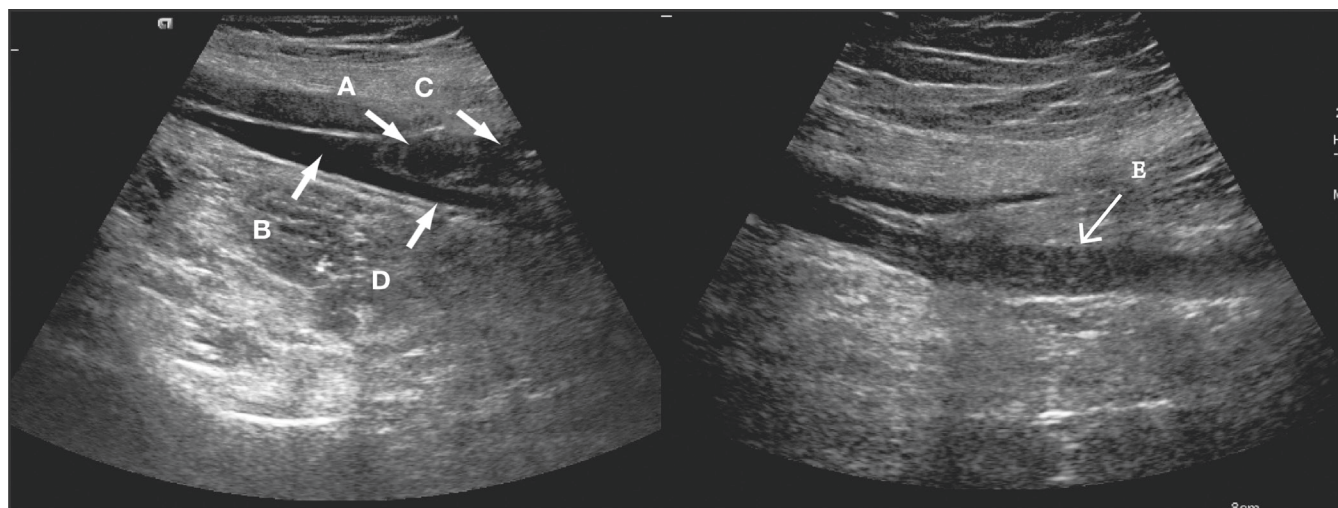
Ultrasound images show formation of DVT in the left lower extremities. (A) Head of the DVT (left). (B) Common femoral vein (left). (C) Superficial femoral vein (left). (D) Deep femoral vein (left). (E) Middle and lower segments of the superficial femoral vein (left). Abbreviation: DVT, deep vein thrombosis.
